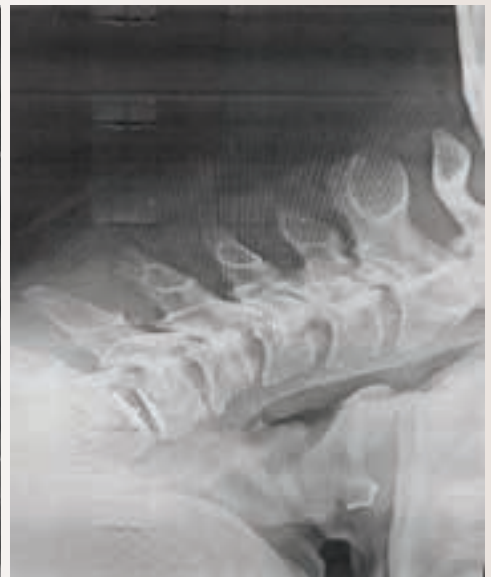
X-rays of a patient from our study now 10 years post-procedure (a) extending and (b) flexing her neck. The prosthesis is functioning perfectly.
